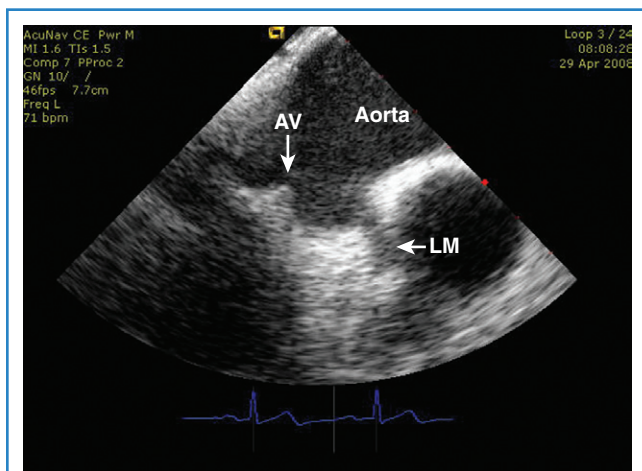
Intracardiac echocardiography image of the aortic valve (AV) and proximal aorta in longitudinal view. Note the left main coronary artery (LM) arising from the left coronary cusp.
